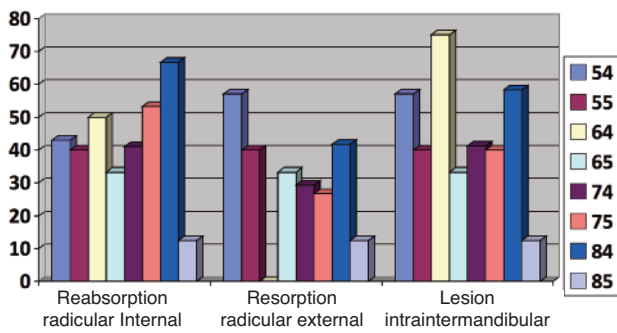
Percentage of pathological radiographic signs in temporary molars in those who had undergone pulpotomy.
